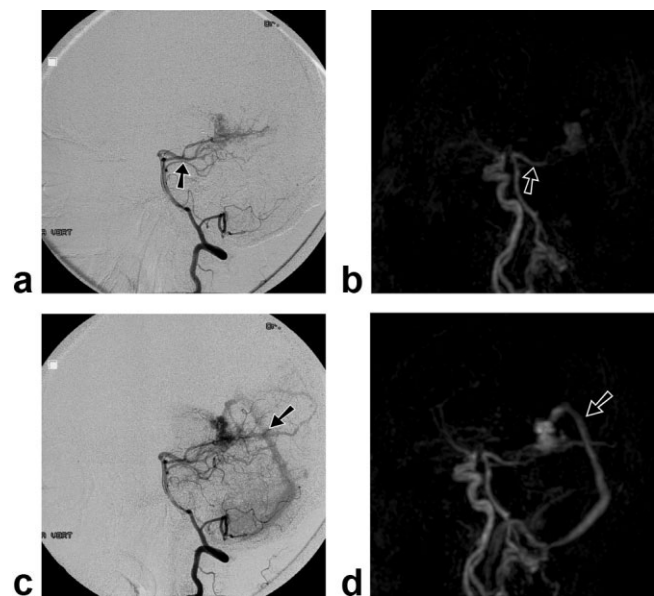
Two dynamic phases (b,d; maximum intensity projections; sagittal) of the 3D T1-weighted gradient echo sequence provided by 4D-TRAK displaying the arterial feeder (posterior cerebral artery; a,b: arrows) and the venous drainage (straight sinus; c,d: arrows) of a left occipital cAVM (nidus size: 2.5 cm) in a 59-year-old male as compared to corresponding phases of lateral views of DSA (a,c) after selective catheterization of the left vertebral artery.
